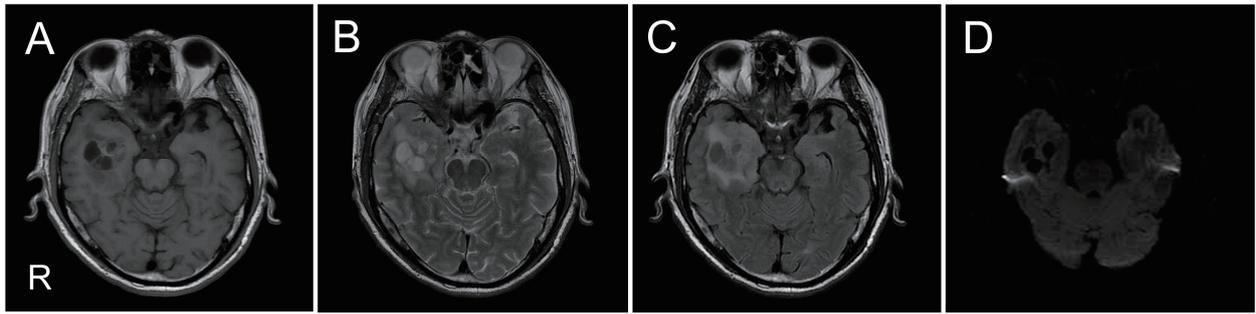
Magnetic resonance image obtained on admission. Axial T1-weighted image (T1WI) (a), a T2-weighted image (T2WI) (b), a fluid-attenuated inversion recovery (FLAIR) (c), and a diffusion-weighted image (DWI) (d). T1WI, T2WI, and FLAIR show a right temporal mass with heterogeneous signal intensity. Note the extensive peritumoral edema (a–c). DWI showing slightly high signal intensity in the tumor (d).
